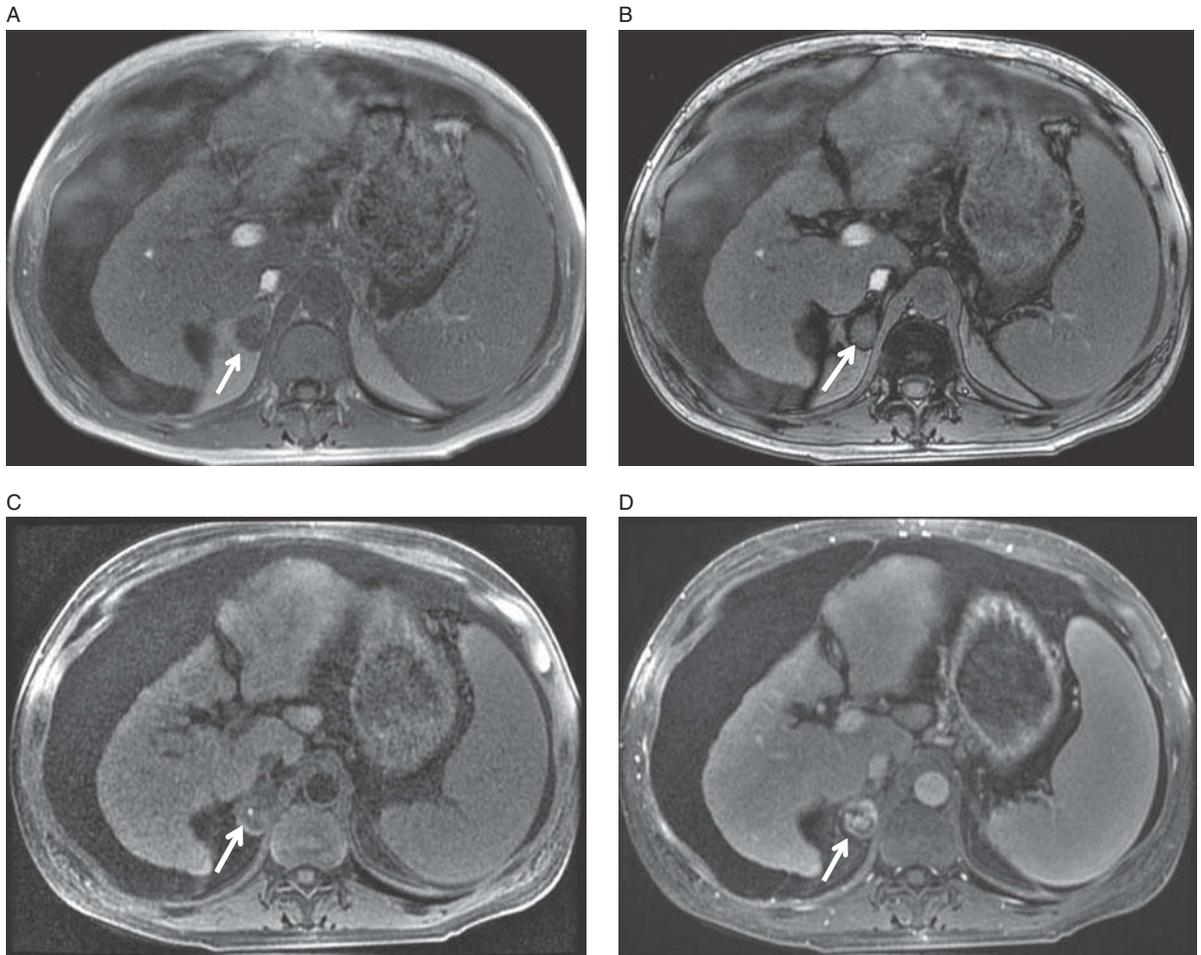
Adrenal metastasis. Arrows indicate right adrenal mass which does not change in signal between in-phase image (A) and out-of-phase image (B). Axial T1-weighted, fat-saturated pre- and post-contrast enhanced images (C, D) demonstrate significant enhancement. Differential diagnosis includes lipid-poor adenoma and metastatic disease. Biopsy revealed metastatic hepatocellular carcinoma; note cirrhosis and ascites.
